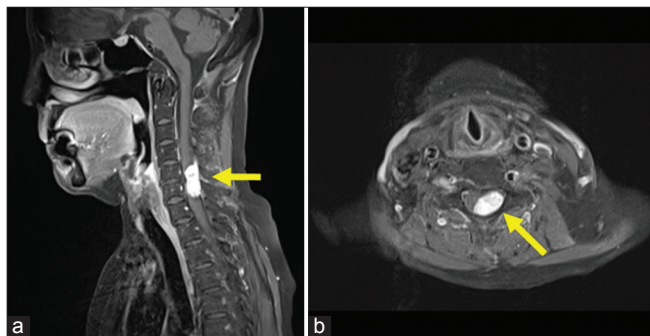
A cervical contrast-enhanced magnetic resonance imaging examination (a and b) showing a 1.4 × 9.0 × 2.3 cm neoplastic lesion (arrow) in the dura mater at the C5-C6 level. This is diagnosed as an intradural extramedullary tumor.
